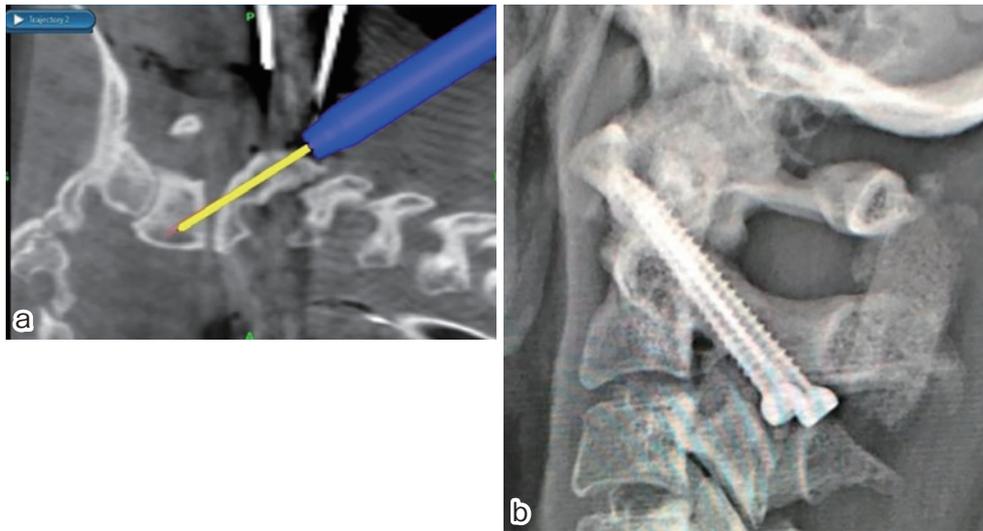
Intraoperative navigation images showing screw holes made with navigated drill guide from the starting point (a). Postoperative X-ray showing proper transarticular screw position (b).
